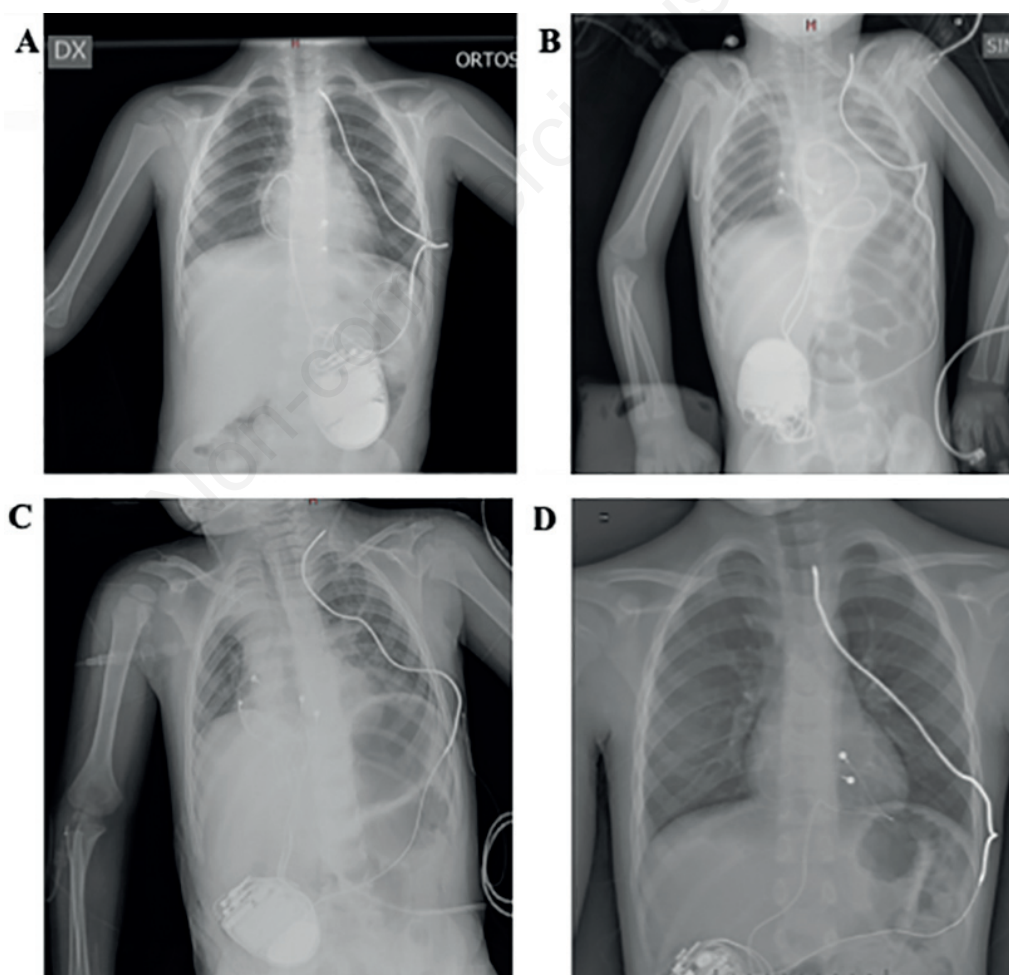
Postimplant chest X-rays. A) Patient #1 (3 years 8 months old/F, 14 kg, 0.61 m² BSA). B) Patient #2 (3 years old/M, 17.5kg, 0.66m² BSA). C) Patient #3 (3 years 5 months old/M, 16 kg, 0.64m² BSA). D) Patient #4 (5 years 6 months old/M, 23 kg, 0.9m² BSA).
